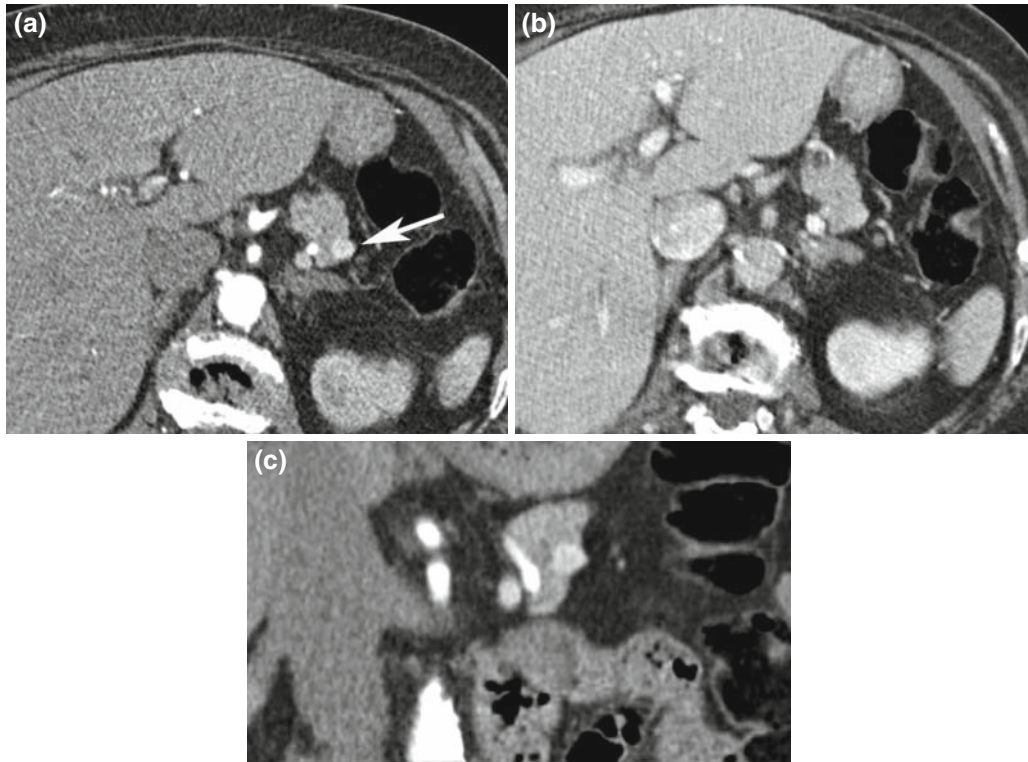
(A) Insulinoma of the pancreatic tail. Axial contrast-enhanced MDCT scan obtained in the arterial phase shows a hyperattenuating lesion in the tail of the pancreas. (B) In the portal-venous phase the lesion is only barely visible. (C): 3D reconstruction of the CT data set in the coronal plane (arterial phase) in the same patient depicts the small hypervascular insulinoma to be very superficial in location.
